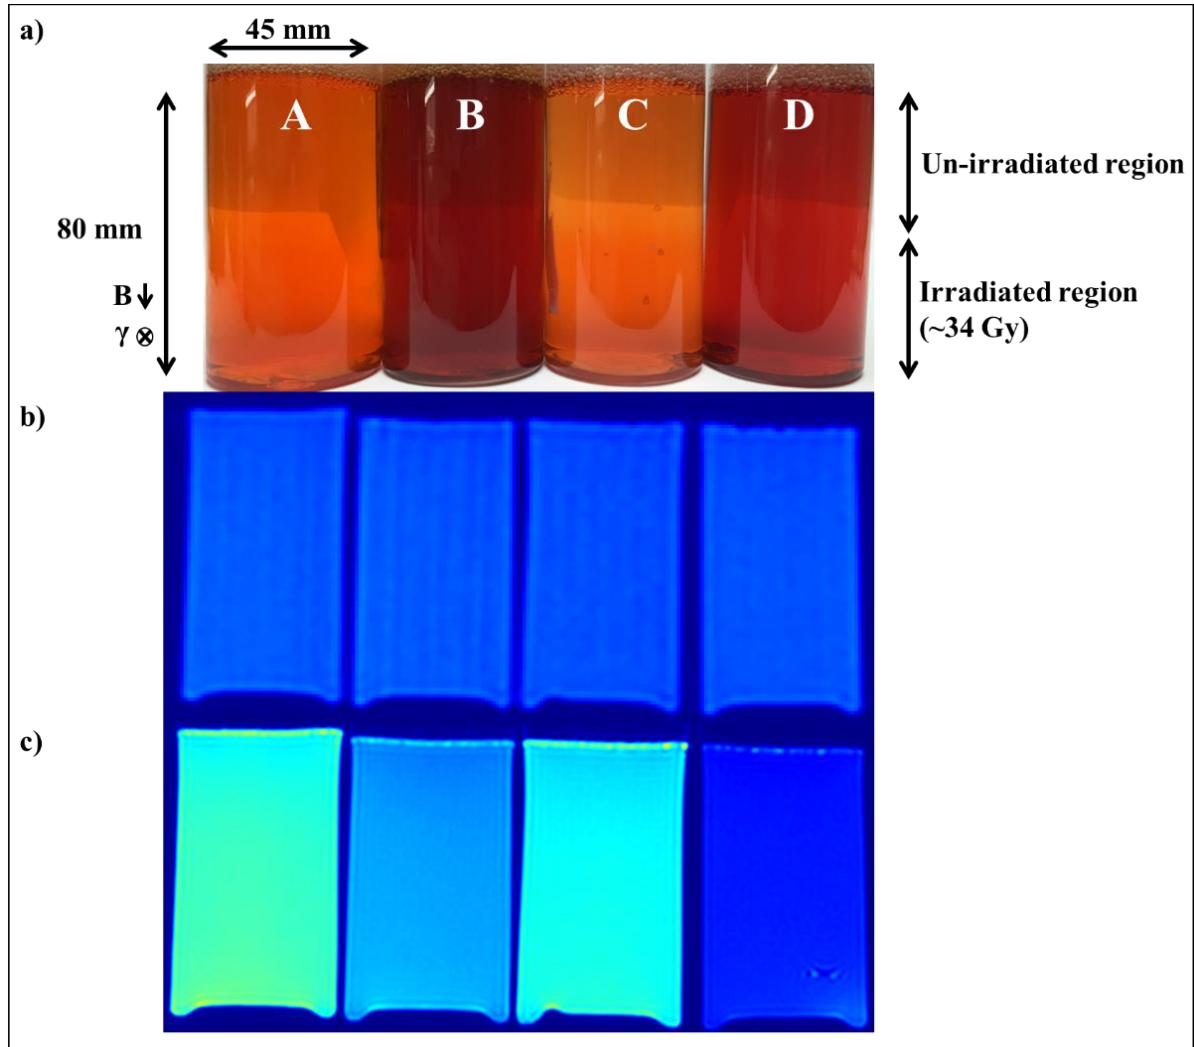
a) Pictures of physical dosimeters where A – FO, B – FCO, C – FB, and D – FCB. The top half of each gel was not irradiated, and the bottom half was irradiated to approximately 34 Gy. b) Snapshots of bFFE acquisitions with $TR/TE = 5/2.4$ ms. c) Post-irradiation acquisitions with TSE $TR/TE = 500/20$ ms. MR images shown with color instead of grayscale to emphasize contrast.
